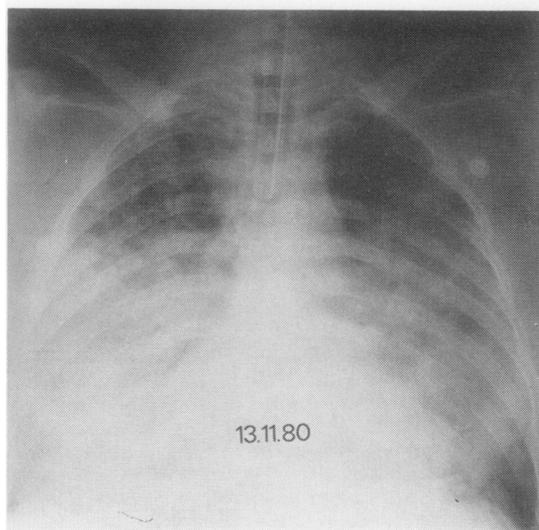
Figure Case 1. Chest radiographs taken a day after starting vidarabine (13.11.80) and eight days later (21.11.80).
